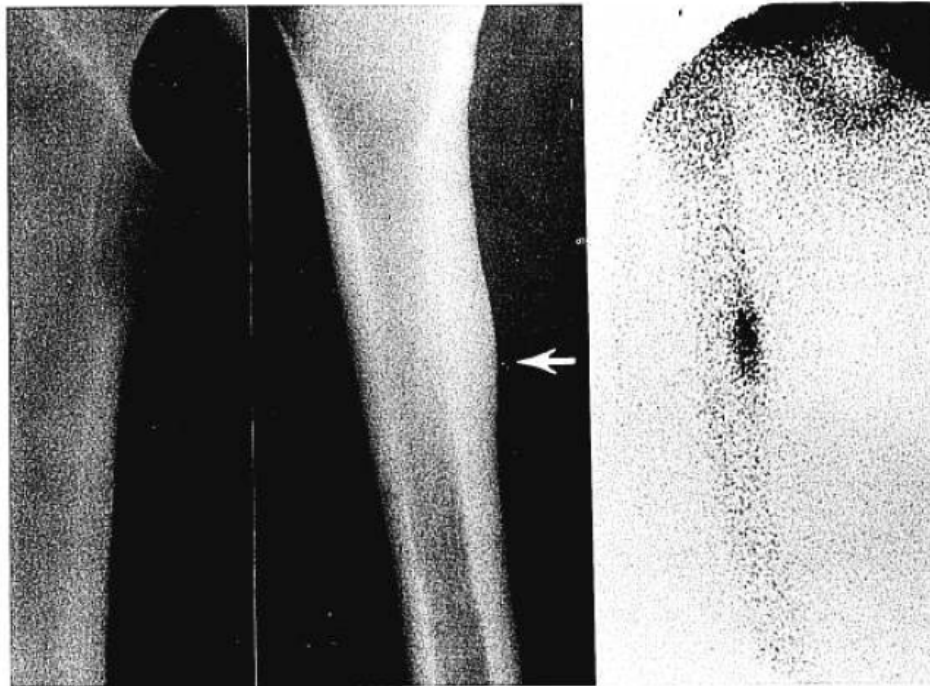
(Patient 10) (Left) Oblique roentgenogram of right femur shows no fracture. (Center) Delayed anteroposterior roentgenogram shows focal area of periosteal new bone formation (stress fracture) just below lesser trochanter (arrow). (Right) Scintiscan shows focal area of increased activity just below lesser trochanter at stress fracture site.
